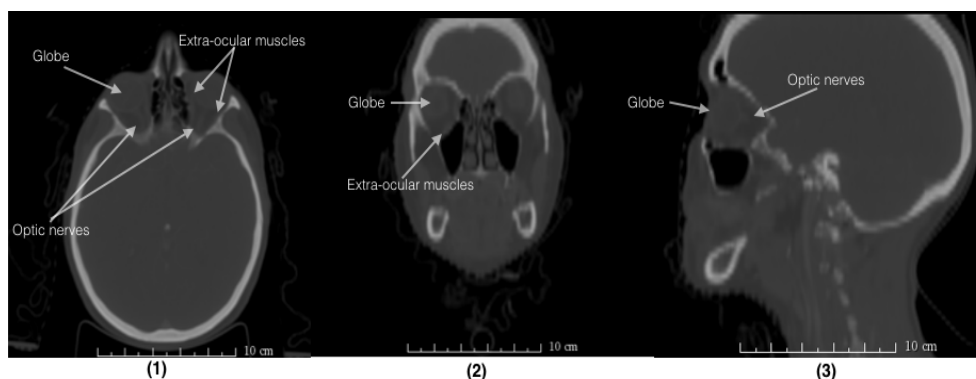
Segmentation of desired structures (optic nerve, eye globe and extra ocular muscles) is challenging due to small size and low-tissue contrast in CT images
